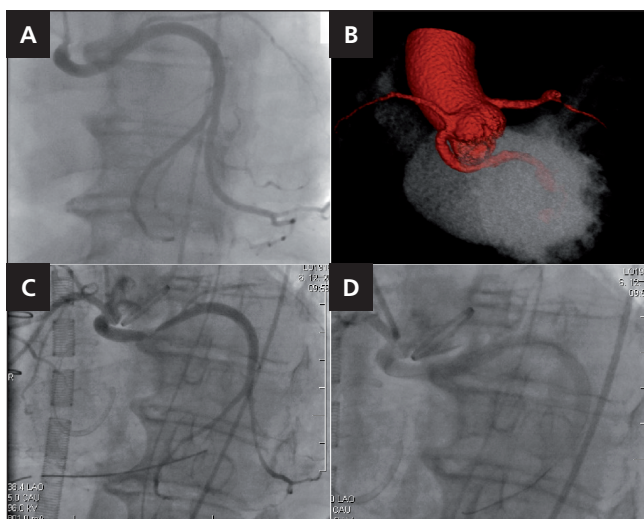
(A) Coronary angiography showing the anomalous left circumflex artery from the right sinus of Valsalva. (B) Cardiac computed tomography showing the anomalous left circumflex artery from the right sinus of Valsalva. (C) Postoperative coronary angiography showing the acute occluded left circumflex artery. (D) Postoperative coronary angiography after successful percutaneous coronary intervention of the occluded left circumflex artery.
